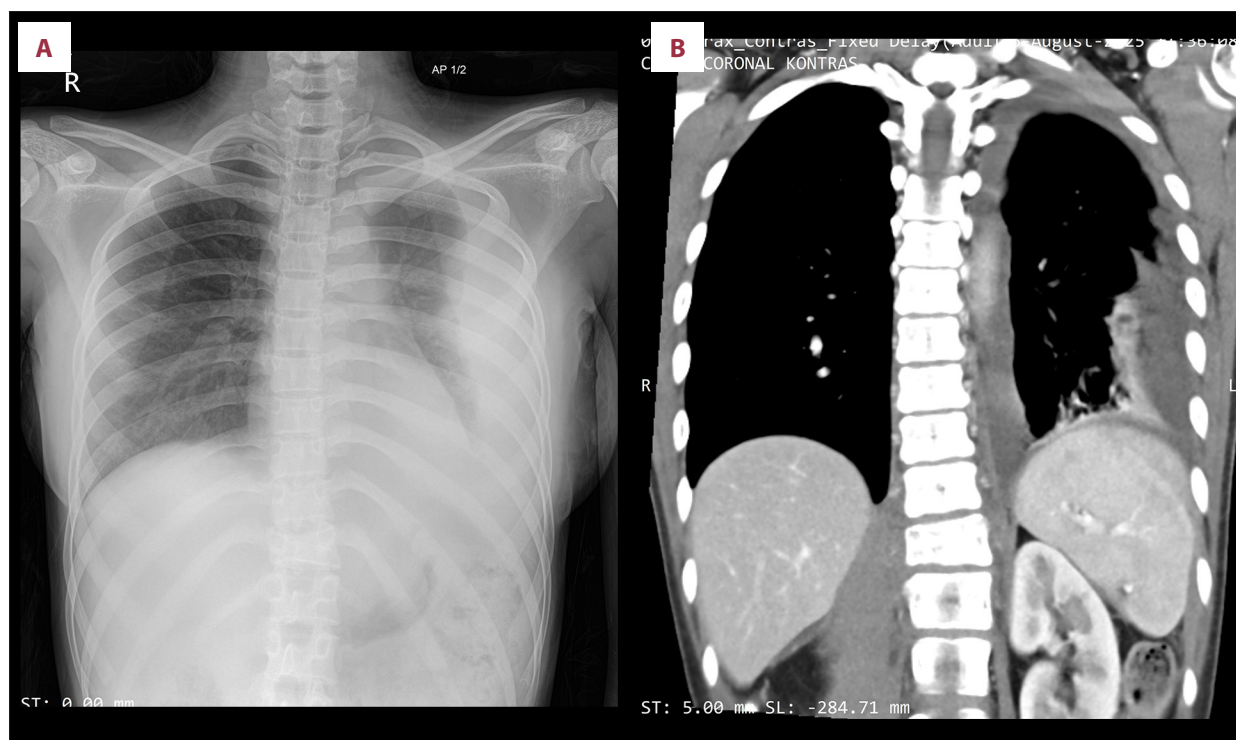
(A) Anteroposterior chest radiograph demonstrating left pleural effusion and compressive atelectasis of the left lower lung. (B) Contrast-enhanced thoracic computed tomography scan demonstrating infiltration of the T7-T12 vertebrae and epidural space.
